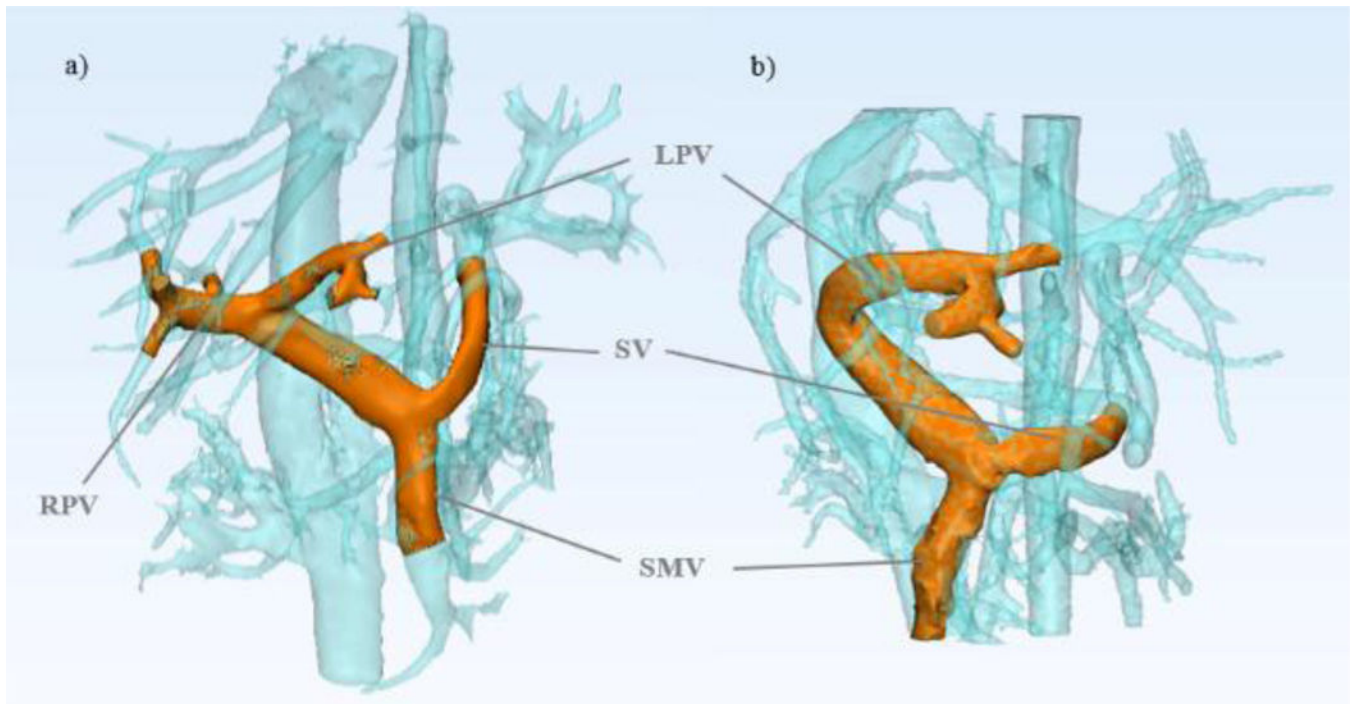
4D flow MRI can be used to depict in vivo anatomy before and after partial hepatectomy in healthy living donors. The models shown were created from MR image data for a) Pre-surgery donor 1 portal vasculature and b) Post-surgery donor 1 portal vasculature.
